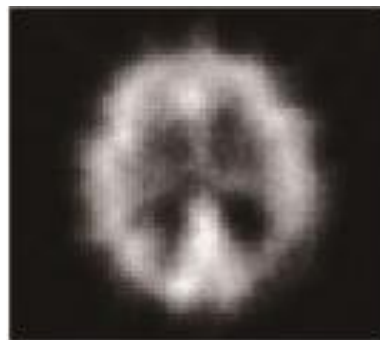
Transaxial brain image from SPECT
